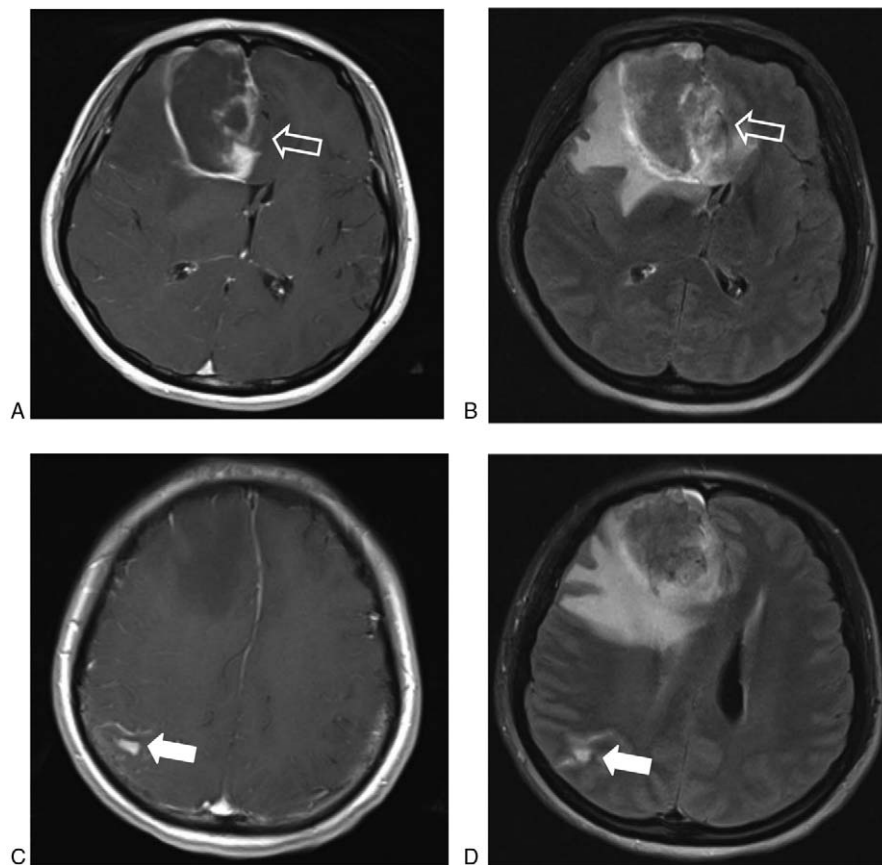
Magnetic resonance imaging (MRI) scan of the brain. (A) Postcontrast T1WI image showed a lesion in the right frontal lobe with ring-like enhancement (*empty arrow*). (B) T2 FLAIR showed a lesion with isointensity or slightly high signal intensity in the right frontal lobe with surrounding edema (*empty arrow*). (C) Postcontrast T1WI image showed the lesion in the right parietal lobe was strongly enhanced (*white arrow*). (D) T2 FLAIR showed a lesion with slightly high signal intensity in the right parietal lobe without apparent edema (*white arrow*).
